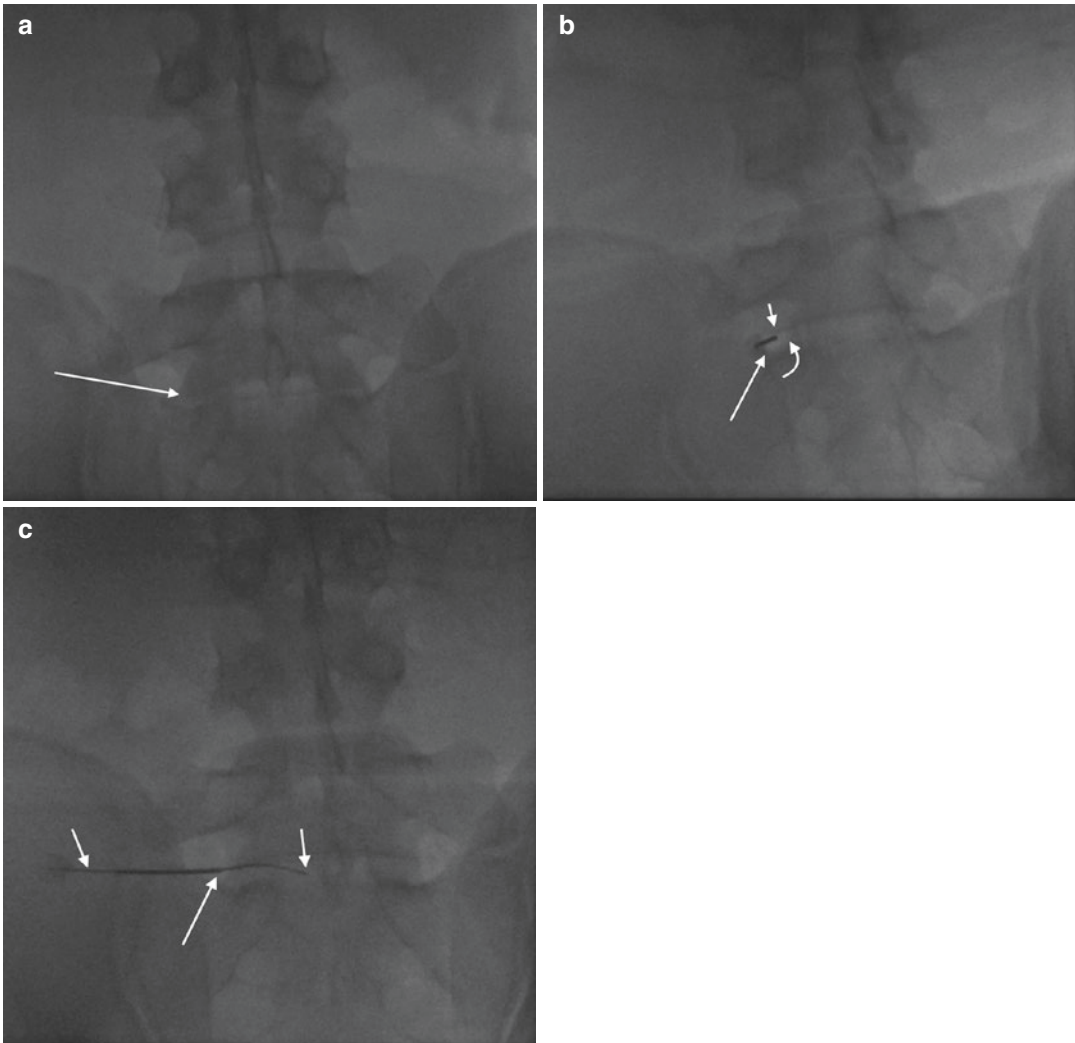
Fluoroscopic approach to the L5-S1 disk space. Frontal radiograph (a) shows L5-S1 disk (arrow). In order to access this disk space, the fluoroscope is angled both in the craniocaudal direction, so as to align the vertebral endplates at L5-S1, and in an ipsilateral mediolateral orientation so as to keep the iliac crest from obscuring and preventing access to the disk space. The result of these fluoroscopic maneuvers should result in an image (b) that projects the superior articular process of S1
